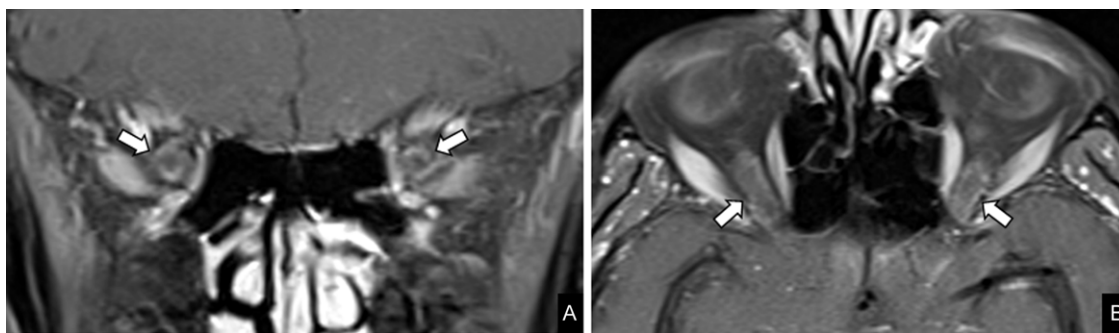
MRI of the orbit. Coronal (A) and axial (B) post-gadolinium T1-weighted Turbo-Spin-Echo (TSE) with fat saturation of the orbit show perioptic enhancement along the intra-orbital segments of bilateral optic nerves (arrows in A and B).
